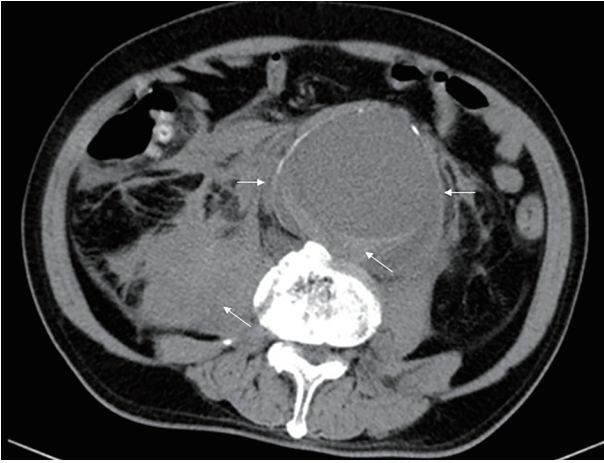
Abdominal CT of Case 2
